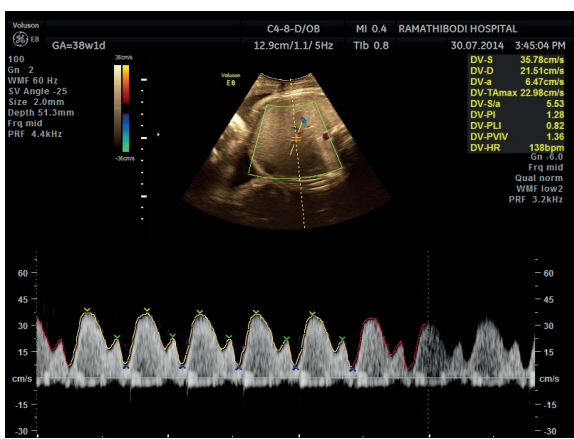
Measurement of ductus venosus Doppler.
